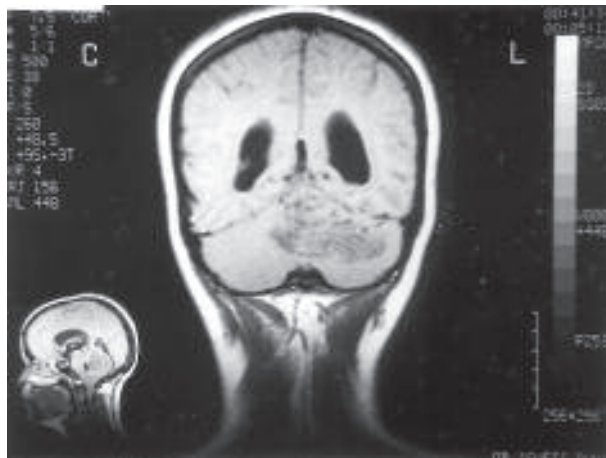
Coronal T1-weighted image shows multiple linear striations consistent with thickened cerebellar folia.
